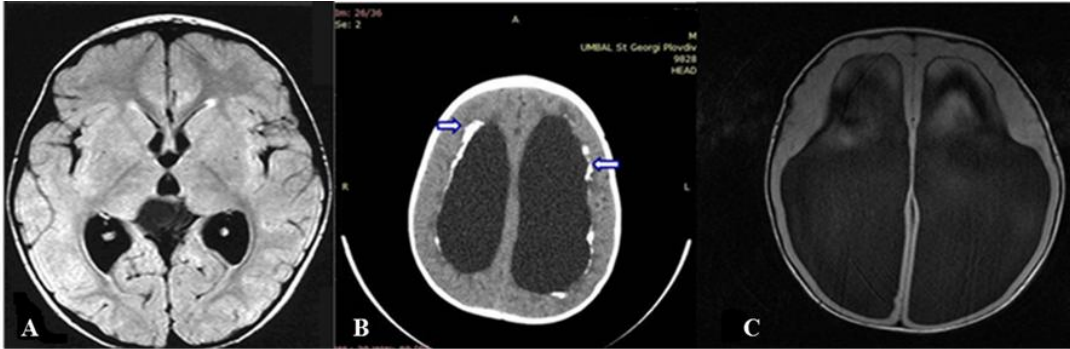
CT images: A/ normal brain ; B/ severe hydrocephalus with transependymal resorption (⇔) ; C/ extreme hydrocephalus
